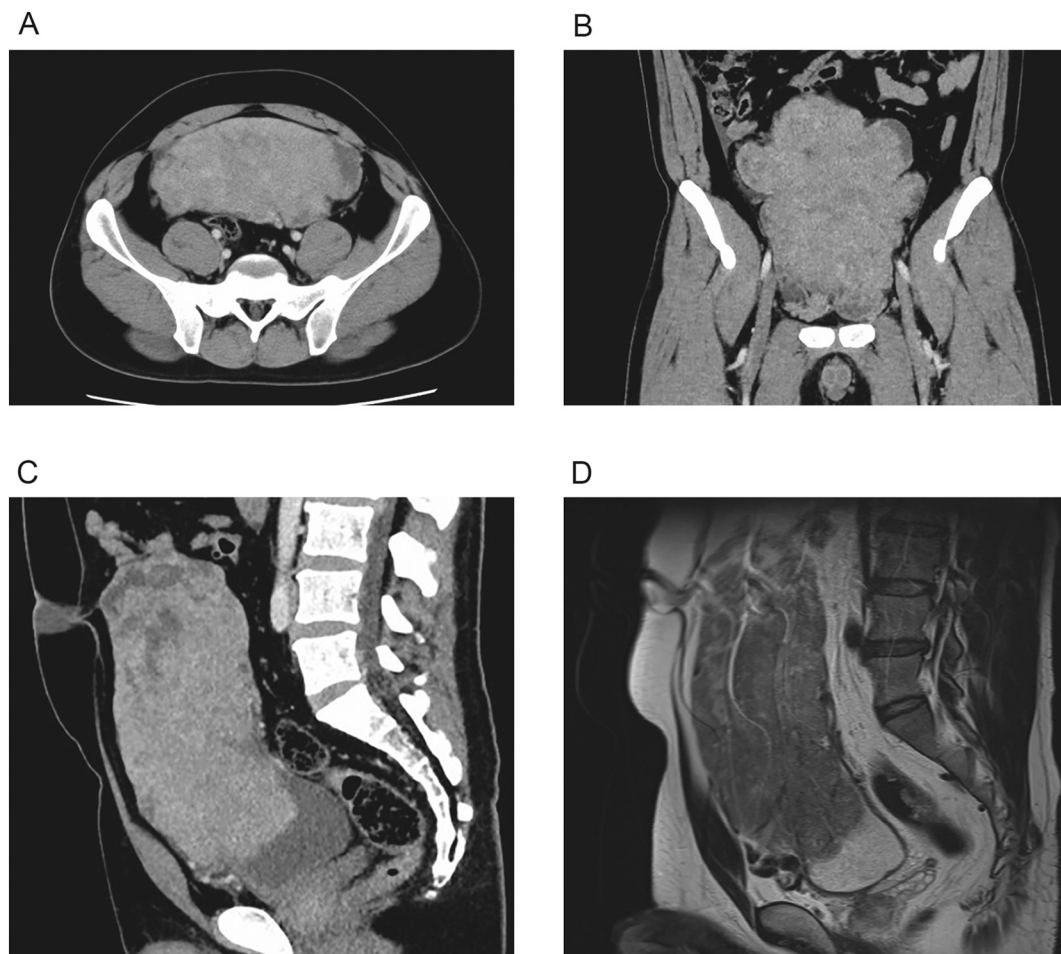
Appearance of radiological examination (CT and MRI).
